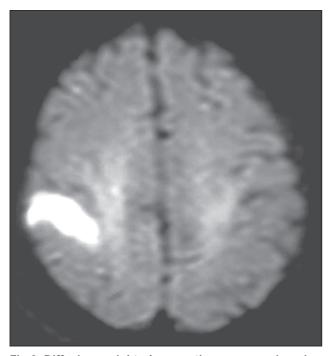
Diffusion-weighted magnetic resonance imaging of an acute cortical cerebral infarct
